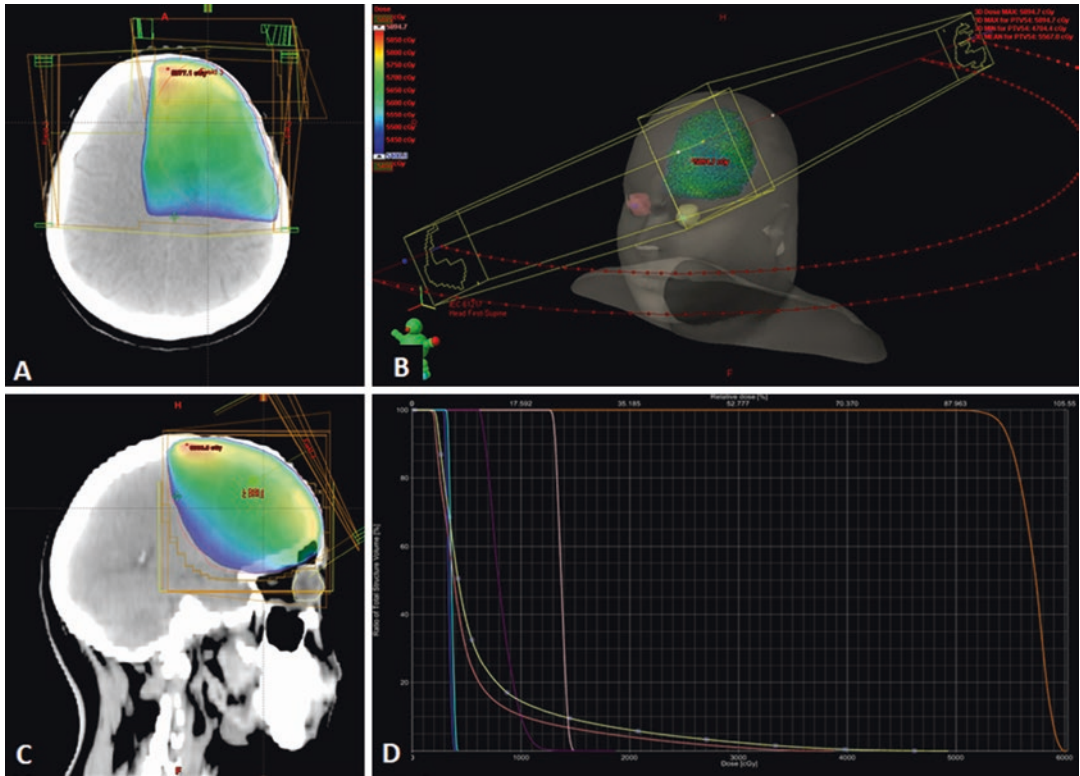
Dose display for 3-D conformal plan. (a) Axial computed tomography (CT) with dose color wash. (b) Three-dimensional view dose color wash. (c) Sagittal CT with dose color wash. (d) The planning target volume
